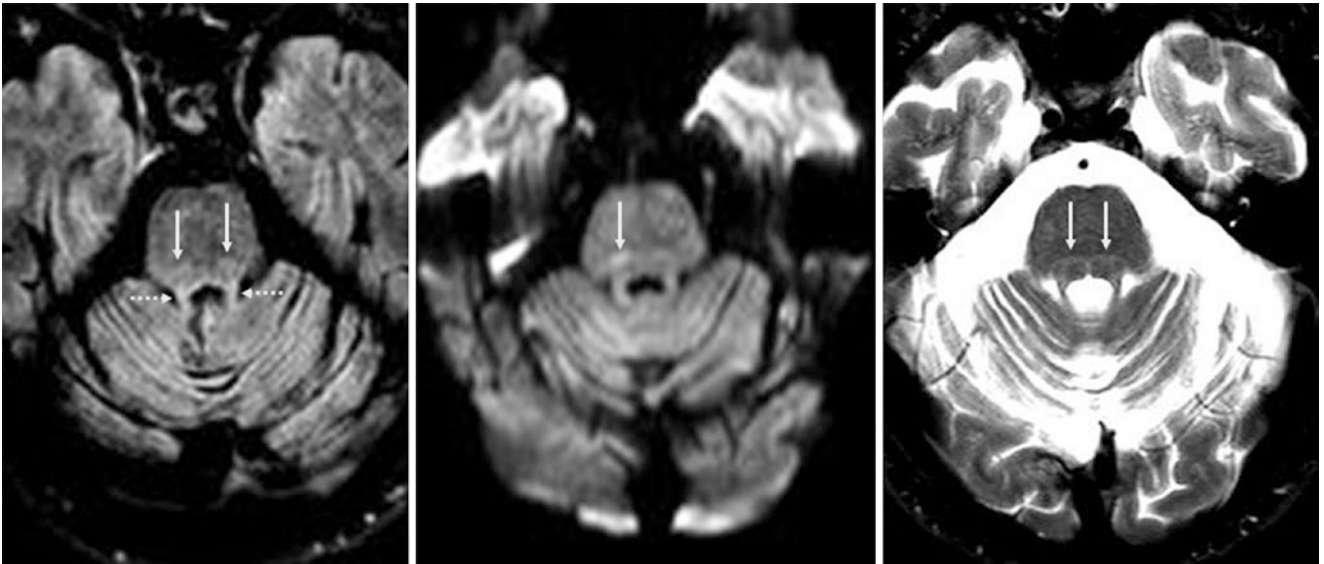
A 59-year-old with headaches had a 3 T MRI with an axial 3D FLAIR reformat (*left*) that depicts normal, mild hyperintensity of the SCPs (*thin dotted arrows*) and medial lemnisci (*long arrows*) within
